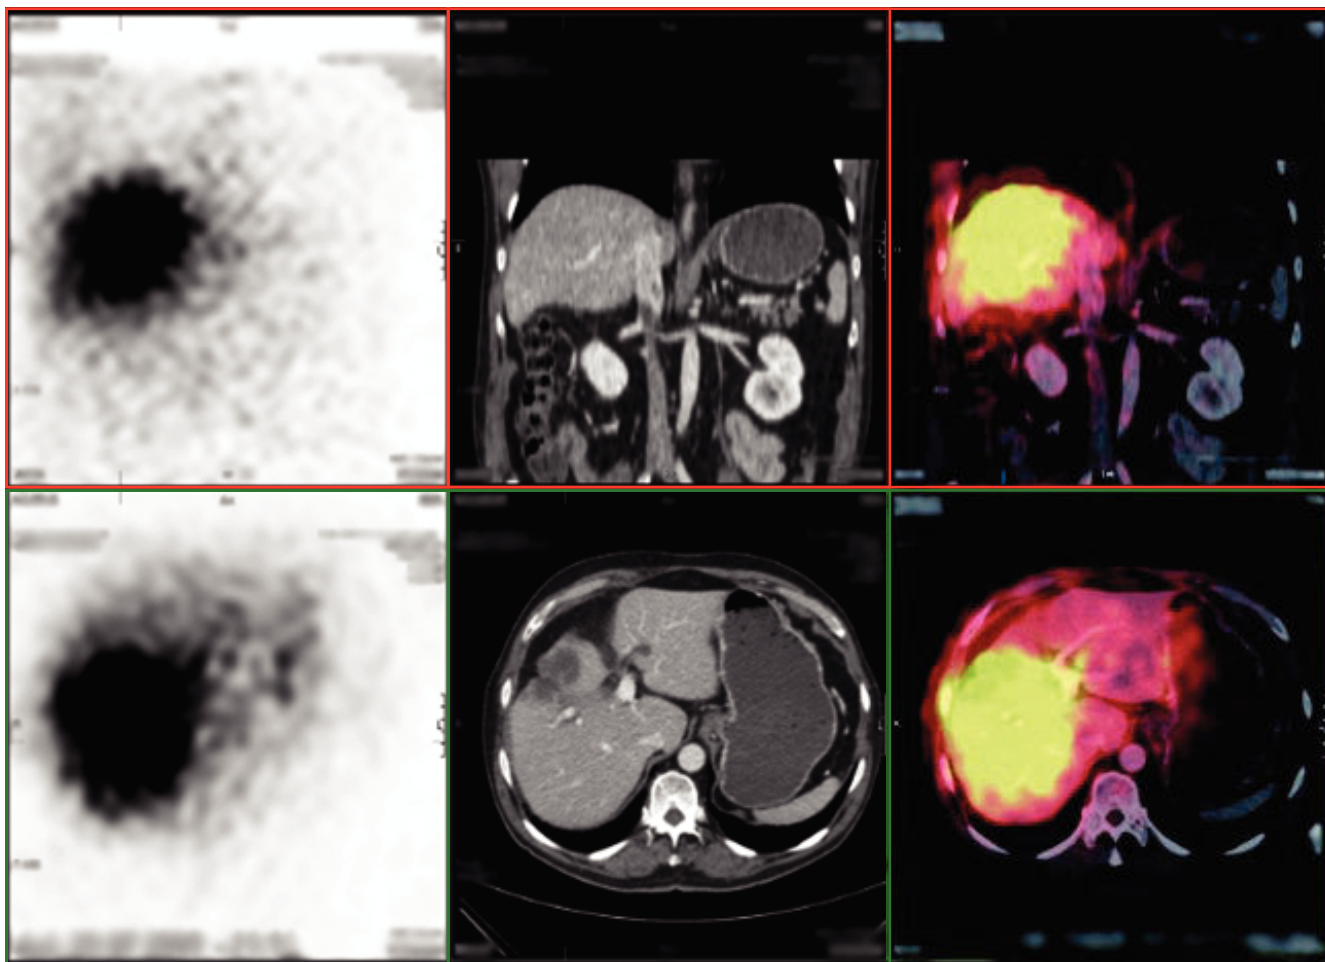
SPECT image, showing the distribution of ^{99m}Tc -MAA, which is used to predict the distribution of the $^{90}\text{yttrium}$ microspheres.
